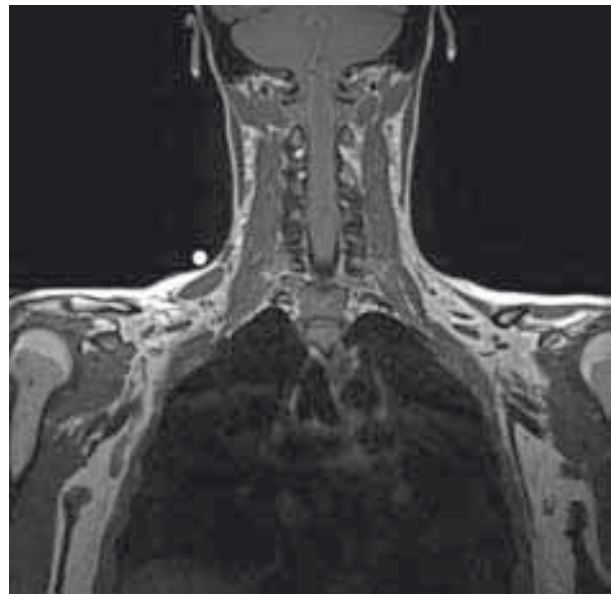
T1 weighted MRI, coronal view, with a marker above the accessory levator claviculae muscle.
